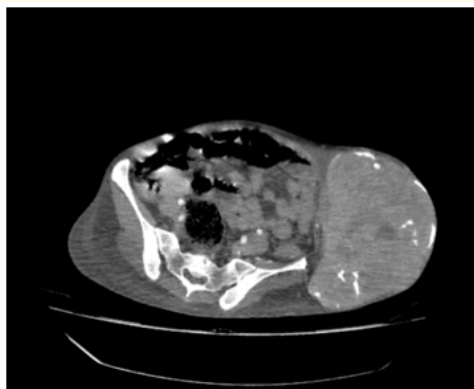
Contrast enhanced CT of abdomen with Squamous gaint cell soft-tissue metastases.
